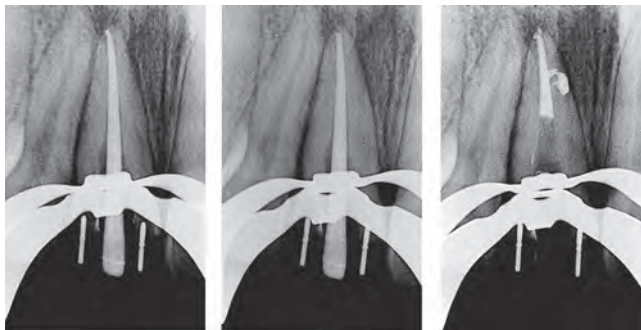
Vertical compaction of warm gutta-percha. Fitting the master gutta-percha cone. The cone is fit to the radiographic terminus. Courtesy of J. West.
